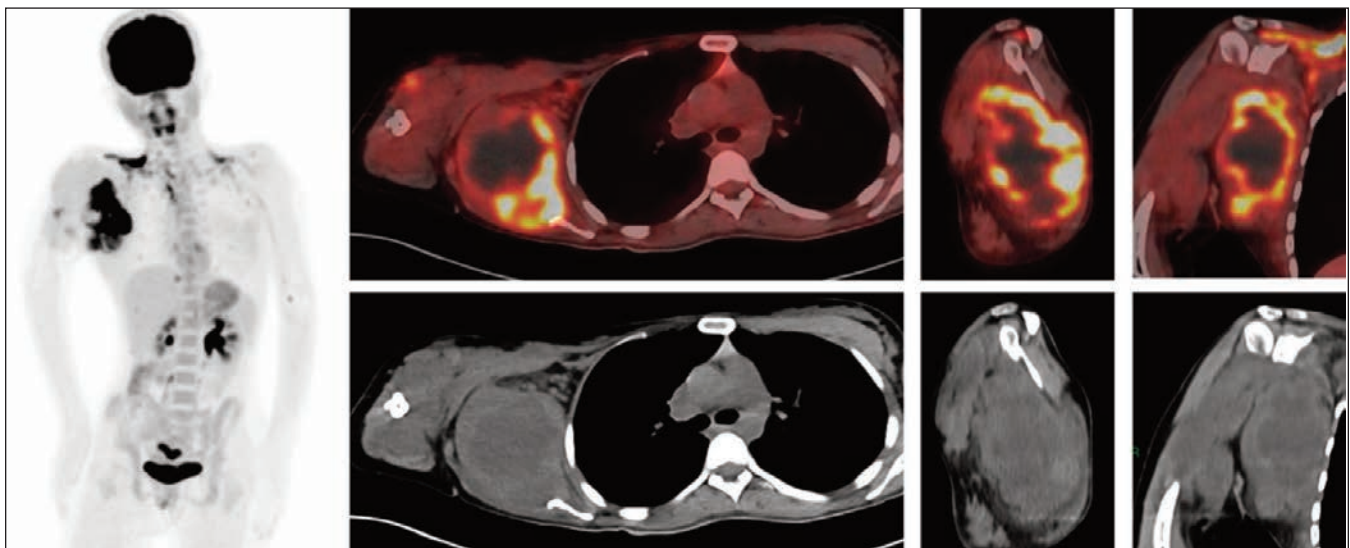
A 20-year-old is known case of neurofibromatosis type 1, presented with large right axillary mass. ¹⁸F-FDG PET/CT images show ¹⁸F-FDG avid lobulated soft tissue lesion (SUV max- 12.8) in right axillary region with areas of hypodensity suggestive of necrosis. The lesion is involving the muscles anterior to scapula. Hypodense lesions with no significant ¹⁸F-FDG uptake are also seen in muscular and subcutaneous planes of adjacent right axilla and right shoulder region. Few areas of focal uptake are seen at this site. Biopsy from large ¹⁸F-FDG avid axillary mass showed malignant peripheral nerve sheath tumour on the background of the neurofibroma. Hypodense lesions with no significant uptake in right shoulder were benign fibromas.
